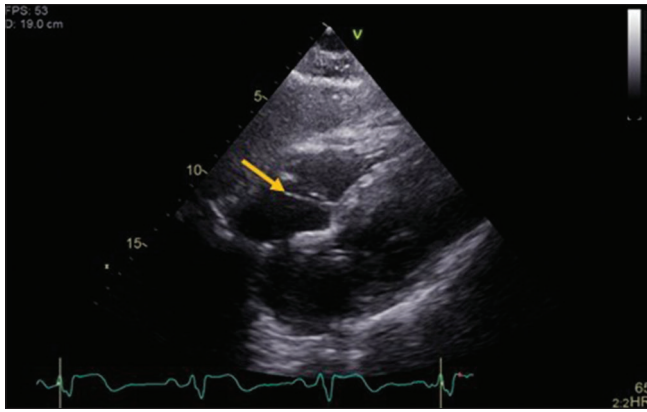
Transthoracic echocardiogram showing temporary pacing wire in the right ventricle
